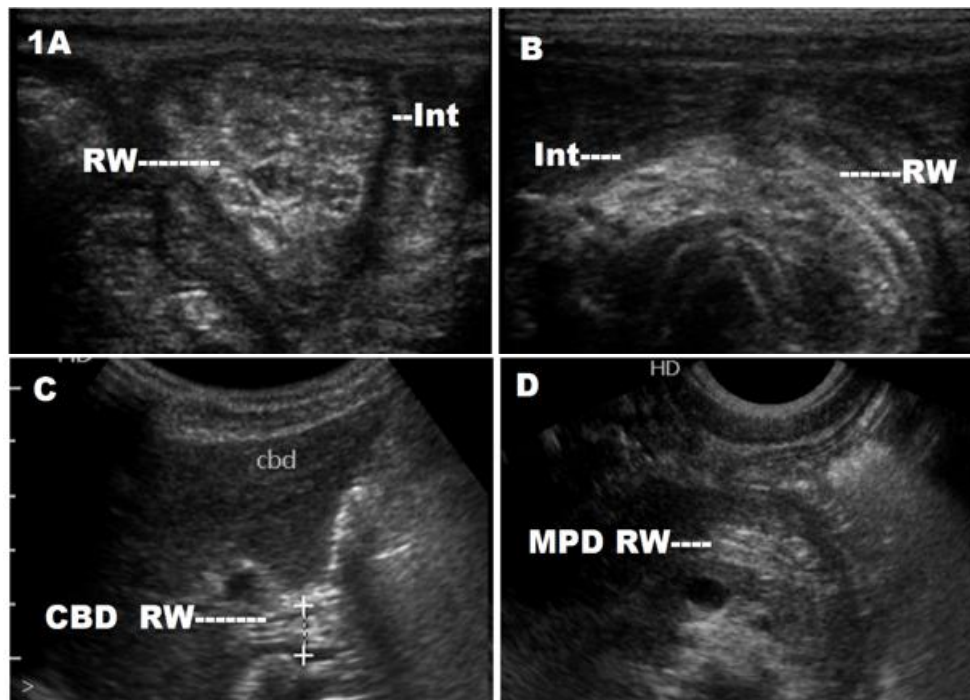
Sonography of Ascariasis. A. Sonography using linear probe showing multiple intestinal (Int) round worms (RW) in cross section forming bag of worms. B. Sonography using linear probe showing multiple intestinal (Int) round worms (RW) seen in long section as tubular structures with 'Inner tube sign'. C. Sonography using curvilinear probe showing round worm (RW) in the common bile duct (CBD). D. Sonography using transvaginal probe showing round worms (RW) in the main pancreatic duct (MPD).
